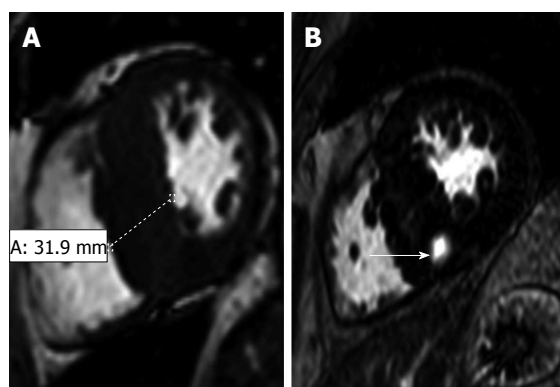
Hypertrophic cardiomyopathy in a 57-year-old man with a 2-year history of exertional dyspnea and chest discomfort who underwent implantable cardioverter-defibrillator placement for primary prevention of sudden cardiac death^[109]. A: Short-axis 2D SSFP magnetic resonance imaging (MRI) performed in end diastole shows asymmetric septal hypertrophy with a maximal thickness of 31.9 mm encroaching on the ventricular lumen; B: Short-axis late contrast-enhanced MRI shows a patchy nodular area of enhancement in the hypertrophied septum (arrow) that does not correspond to a coronary artery territory and, therefore, is distinctly different from an infarct scar.
